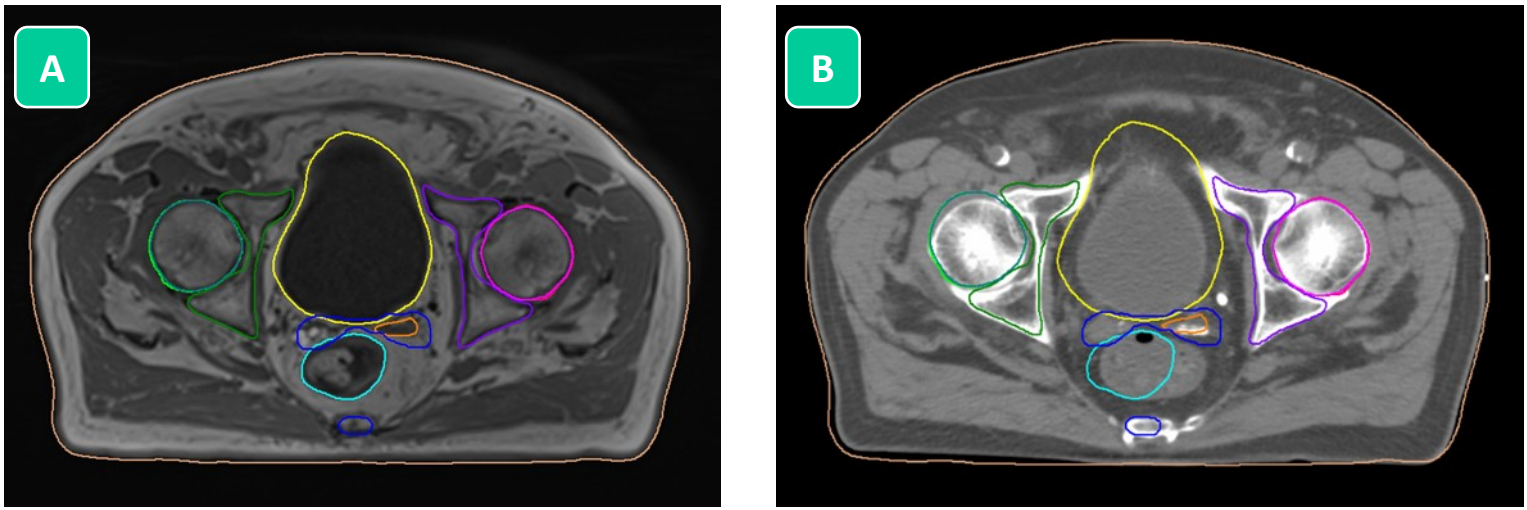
Example of difference in patient anatomy between two different and consecutive acquisition, carried out with a same training. On the left, the MR images (A), while on the right the CT images where structures contoured on MR are copied (B).
